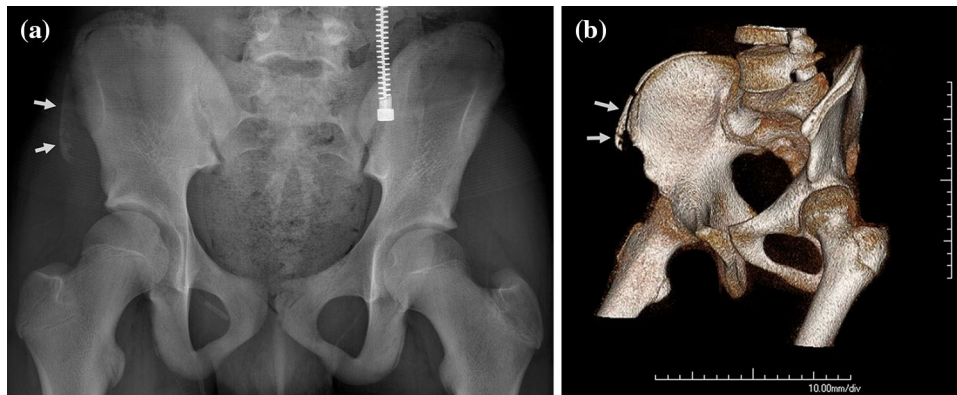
A 15-year-old boy with anterior superior iliac spine avulsion on radiography (a) and 3D CT (b). Avulsion injuries in the pediatric pelvis occur at the junction of the apophysis, synchondrosis, and more central bone and are the result of mechanical forces of the tendon at this weak link
